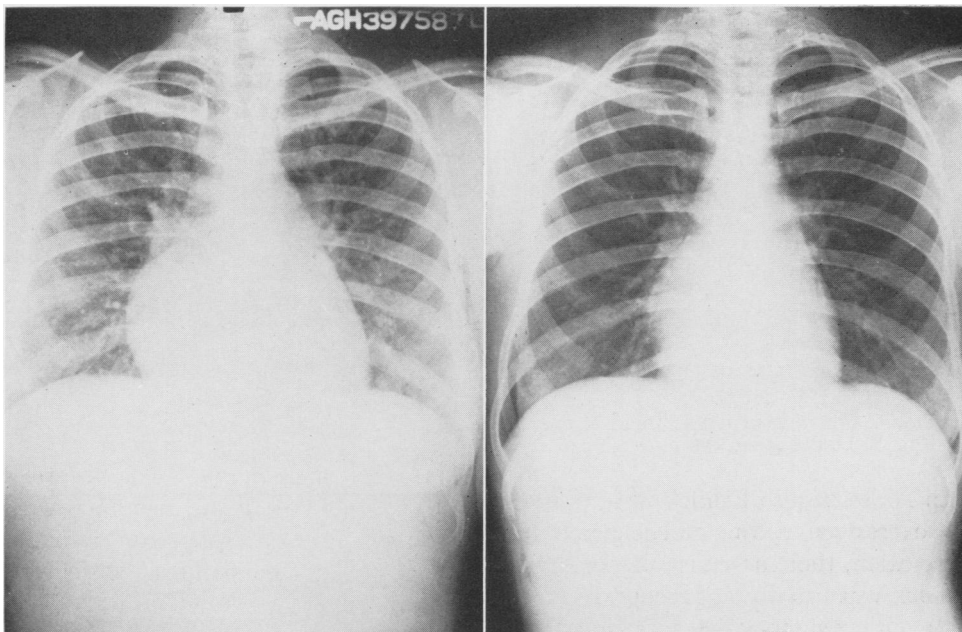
Preoperative roentgenogram of chest showing cardiac enlargement and pulmonary congestion.
